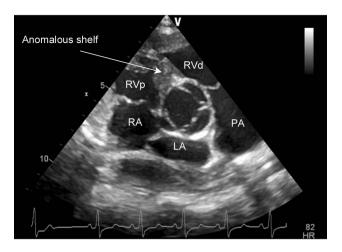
Transthoracic 2-D echocardiogram parasternal short-axis view in systole revealing quadricuspid aortic valve and anomalous shelf in right ventricle.
